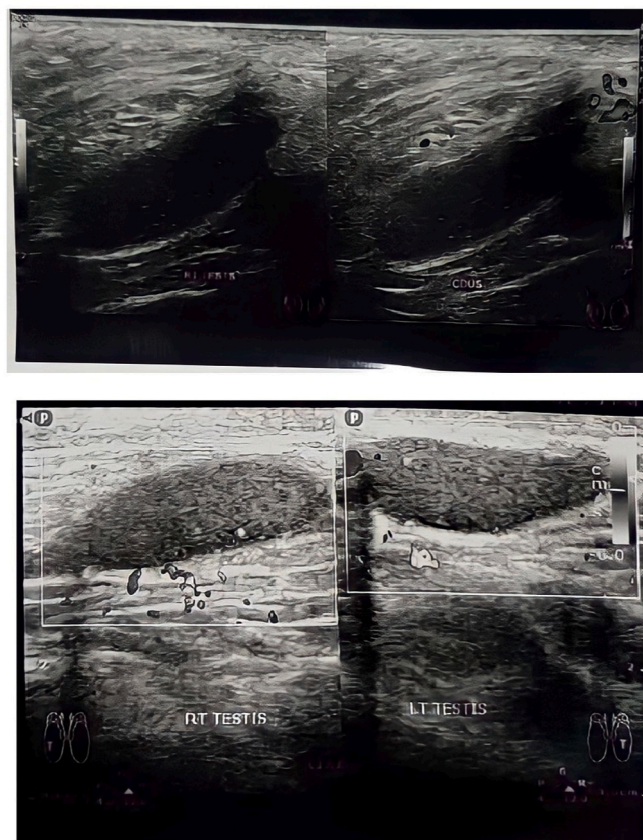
Testicular ultrasound showing bilateral microtestis.
